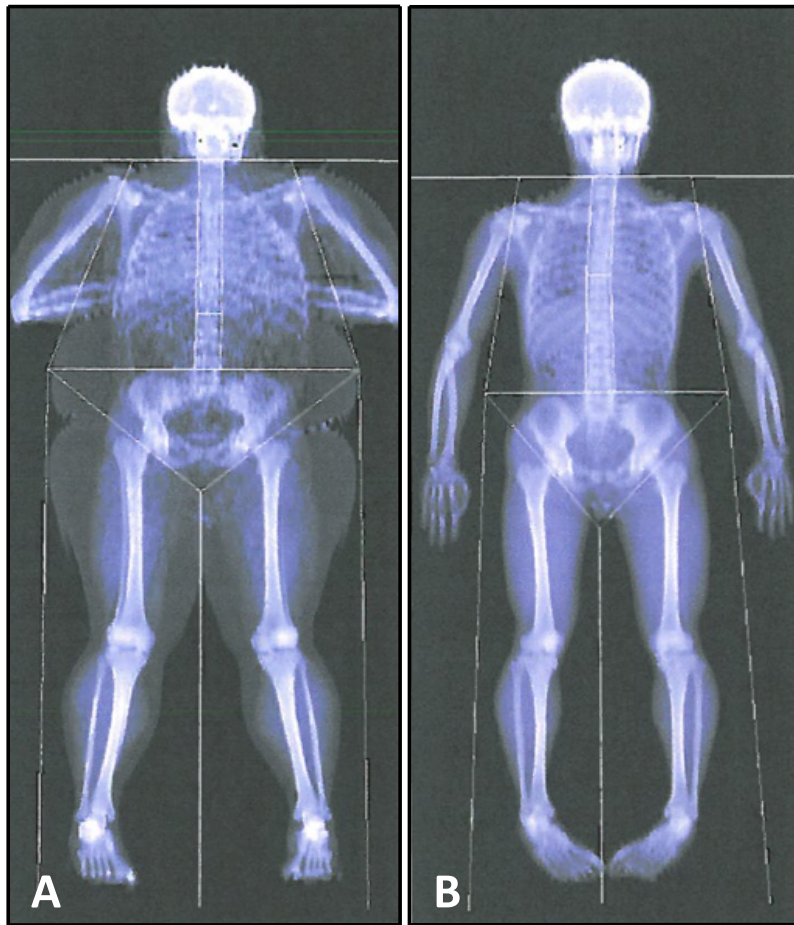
Typical Dual-energy X-ray absorptiometry (DEXA) scan of an A) Obese, and B) Non-obese participant.
